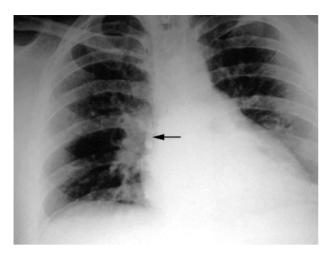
Chest radiograph showing lodged tooth in the right main bronchus
